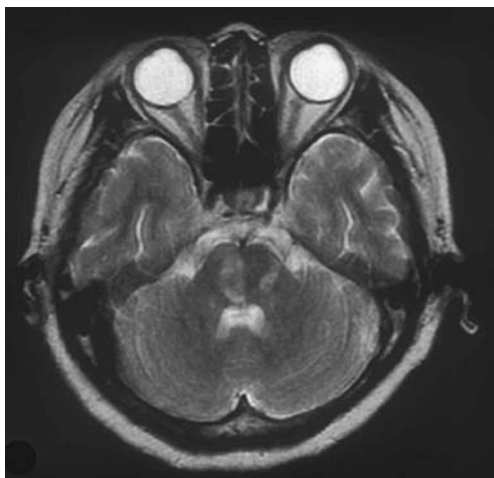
Magnetic resonance image revealing multiple infarctions in the pons
